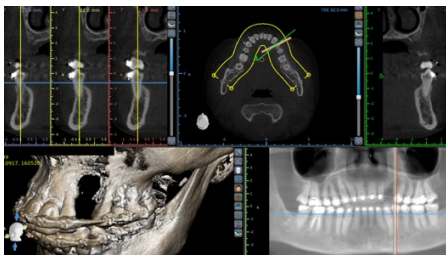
CT scan showing vertical deficiency.
